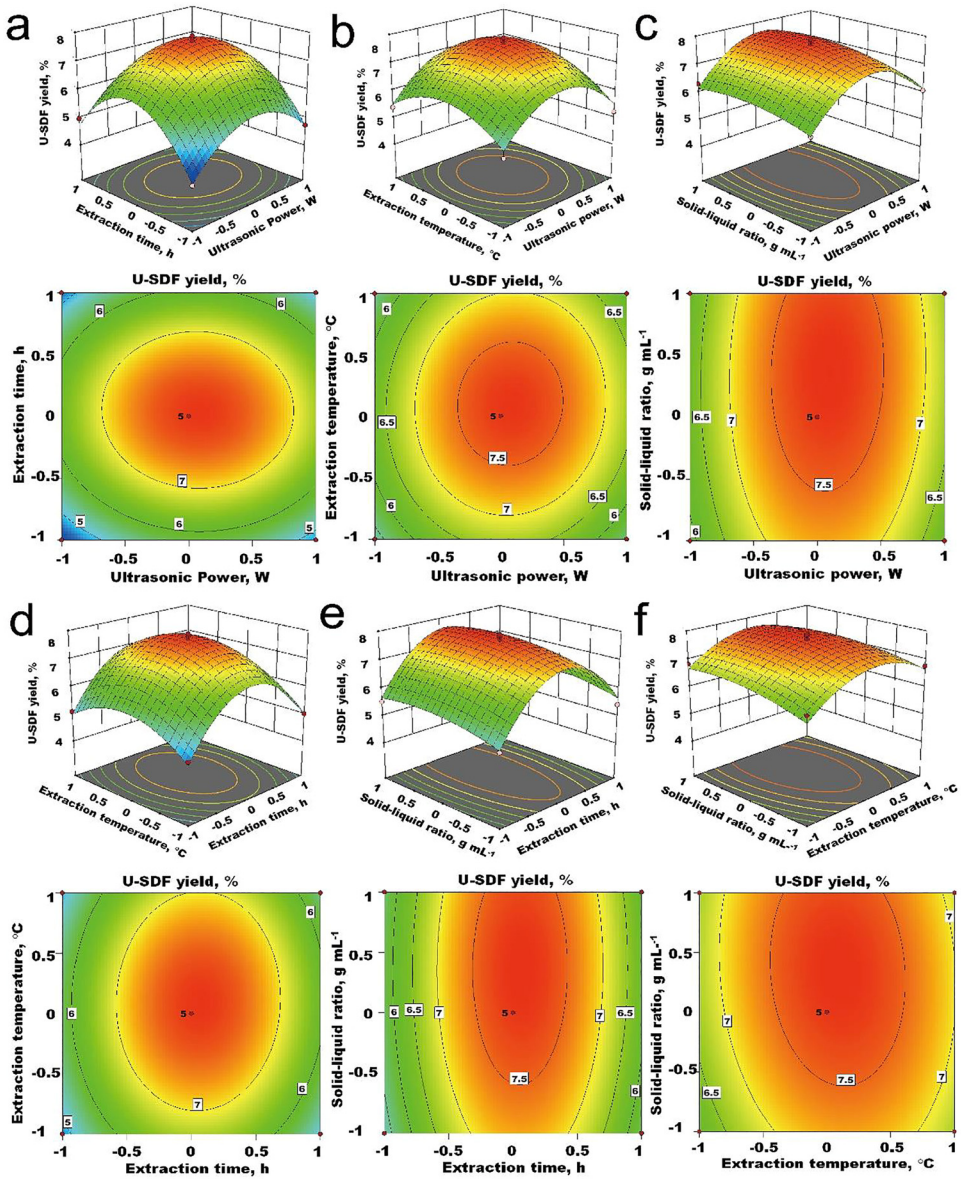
3D-response surface plot and contour plots for optimising extraction conditions, showing the effect of different extraction condition variables (independent factors) on U-SDF yield. (a) ultrasonic power and extraction time; (b) ultrasonic power and extraction temperature; (c) ultrasonic power and solid-liquid ratio; (d) extraction time and extraction temperature; (e) extraction time and solid-liquid ratio; (f) extraction temperature and solid-liquid ratio
